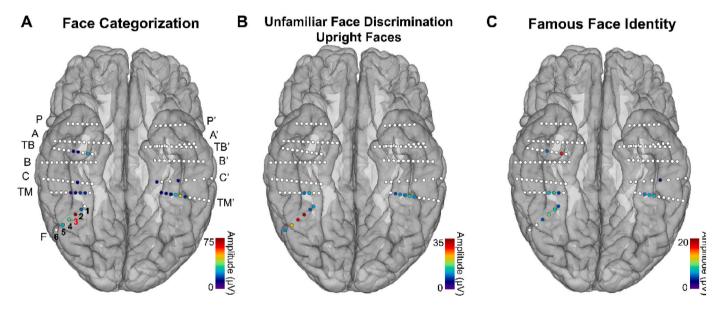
Spatial distribution of intracerebral contacts in CJ's VOTC and significant responses to three FPVS paradigms. A. Amplitudes of significant face-selective responses are plotted for the Face Categorization paradigm. B. Amplitudes of significant unfamiliar face discrimination responses. C. Amplitudes of significant famous face identity responses. Intracerebral contacts located in the VOTC are plotted in the native MRI space of CJ's brain using a reconstructed cortical surface. Each circle represents a single intracerebral contact; white circles depict contacts with no significant response while colored circles indicate significant contacts and their respective baseline-corrected amplitude. Each electrode's name is displayed on its outer side and contacts are numerically labelled, i.e., F1 is the most medial contact of electrode F and F6 is its most lateral contact. Contact F3 eliciting the strongest FPVS responses and the most reproducible electrical stimulation effects is highlighted in red.
